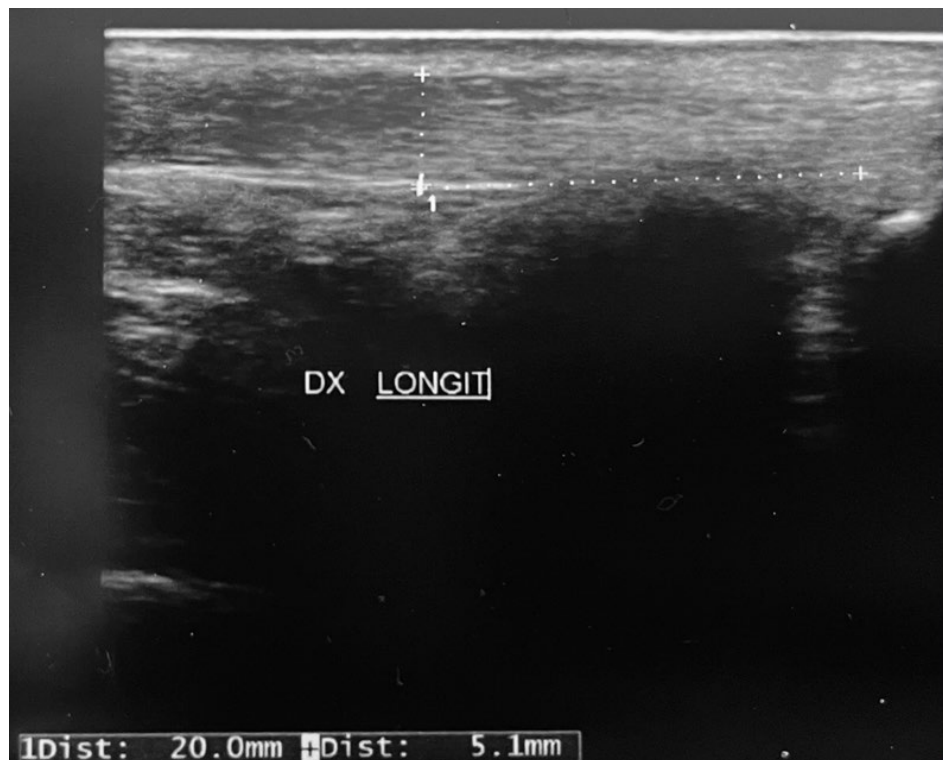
The ultrasound finding shows a thickening of the Achilles tendon and diffusely hypoechoic superficial areas 2 cm from the insertion on the calcaneus.
